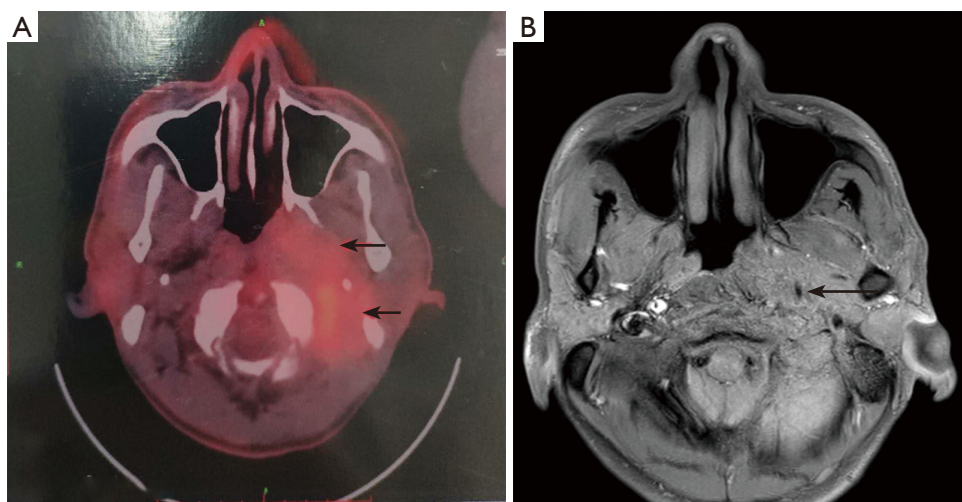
Patient's imaging results before treatment. The arrow indicates the tumor area. (A) PET showed a soft-tissue lump in the left wall of the nasopharynx (SUVmax 3.8), down to the level of the oropharynx, up into the brain, and multiple enlarged lymph nodes in the double neck area II. (B) Before treatment, MRI showed irregular long T1 and iso-T2 signals in the left parapharyngeal space. The boundary of the lesion was unclear. The mass invaded the nasopharynx, went outward to the parotid gland, upward to the left external auditory meatus, through the foramen magnum, and the skull base to the left of the cavernous sinus and posterior cranial fossa, and destroyed the adjacent bone. PET, positron emission tomography; SUVmax, maximum standardized uptake value; MRI, magnetic resonance imaging.
